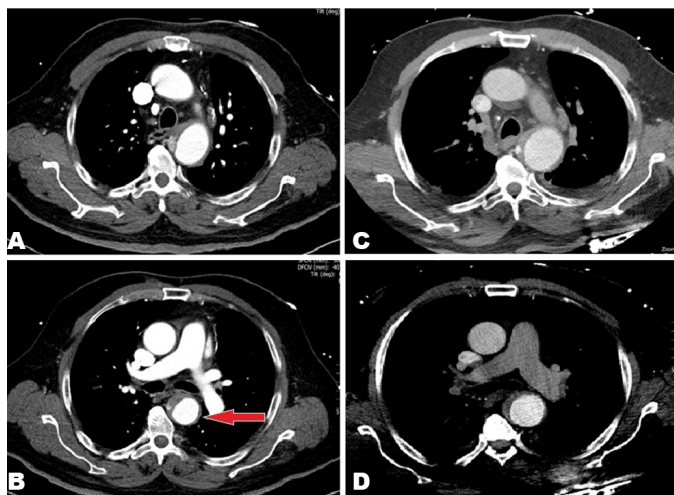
Computed tomography scan images 24 hours later the intramural hematoma has reduced significantly from day-1 (A, B) compared to day-2 (C, D).
